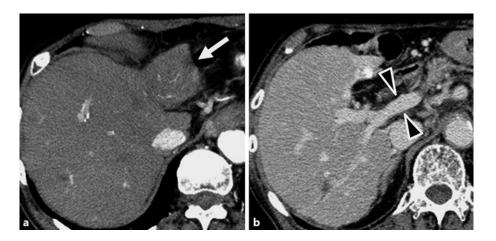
Contrast-enhanced computed tomography scan performed 16 months after conventional transcatheter arterial chemoembolization showed disappearance of the diffuse high-density area in the left lobe during the arterial phase (a) (white arrow) as well as of the tumor thrombus in the main portal vein during the delayed phase (b) (arrowheads). Atrophy of the left lobe was observed.
